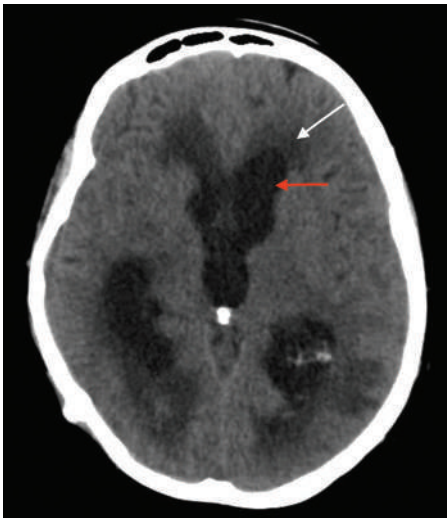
Computed tomography (CT) scan showing hydrocephalus (white arrow) and transependymal edema (red arrow)
